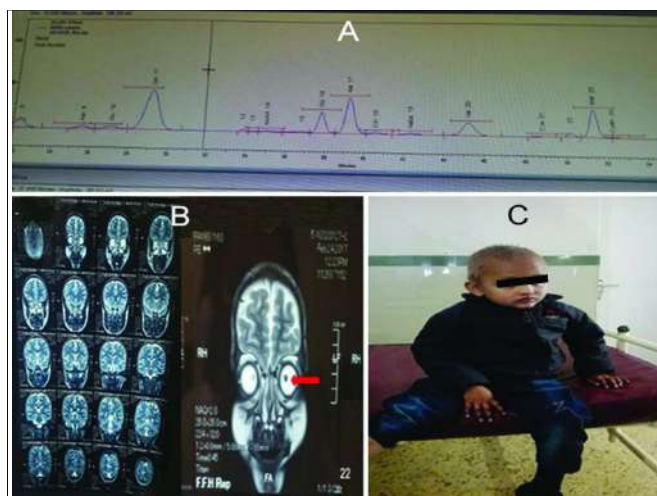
(C) Frontal view of patient showing relative nonspecific facial features and thin brittle, discolored hairs. (A) Plasma amino acid profile chromatogram showing markedly increased peak of methionine and low peak of cysteine with rest of amino acids had normal chromatogram peaks. (B) MRI showed bilateral medially dislocated lens with no abnormal enhancing area in brain.
